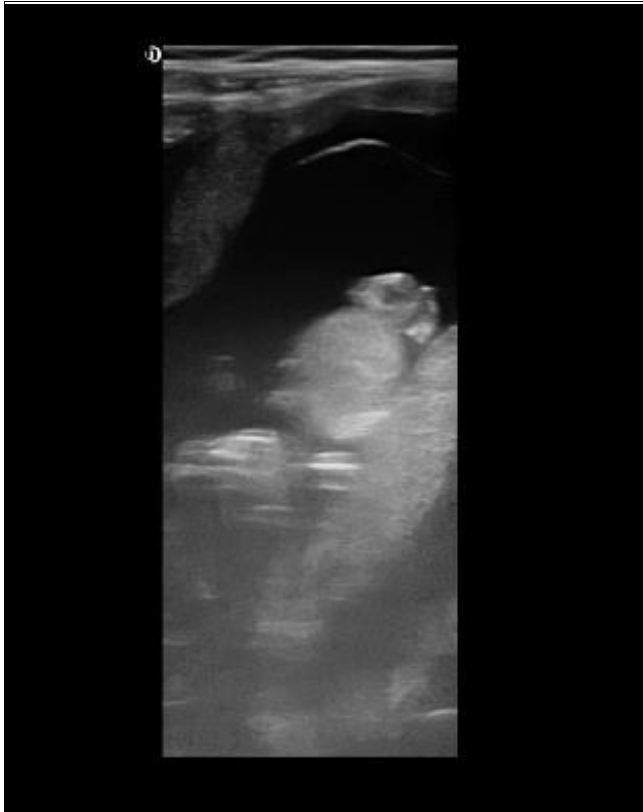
Ultrasound section showing the superficial contours of the mass
